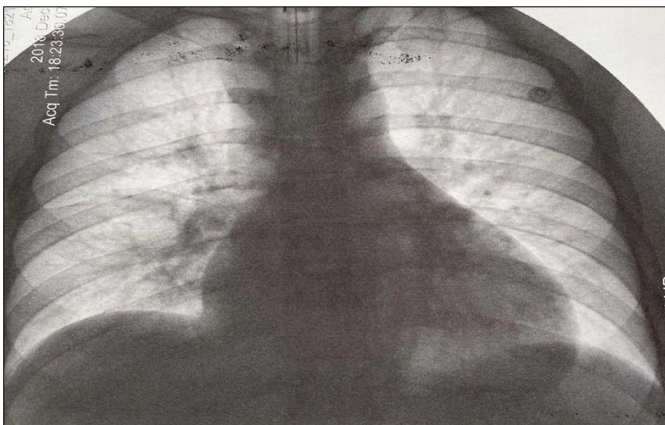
X-ray examination of the chest
